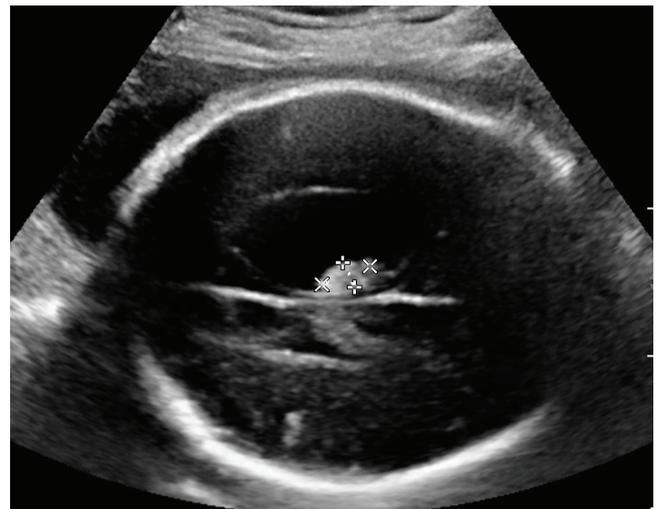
Image demonstrating echogenic intraventricular clot. Ultrasound image showing an echogenic space-occupying lesion. A blood clot (1.2×0.6 cm) was noted in the ventricle with unilateral ventriculomegaly. Postnatal magnetic resonance imaging confirmed the presence of an old intraventricular hemorrhage.
